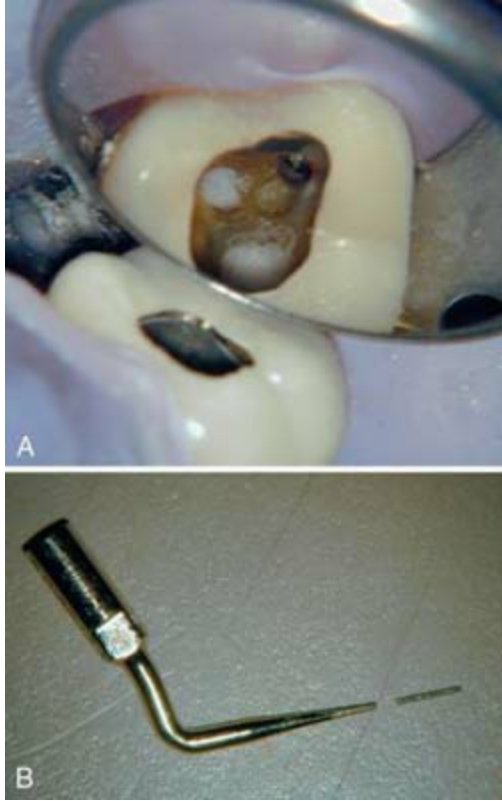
A, Cotton pellets protecting the orifices of the other canals when ultrasonic obstruction removal is needed. B, Ultrasonic tip separated during excavation around separated instrument. If the adjacent canals were not protected, further unnecessary complication could result.
